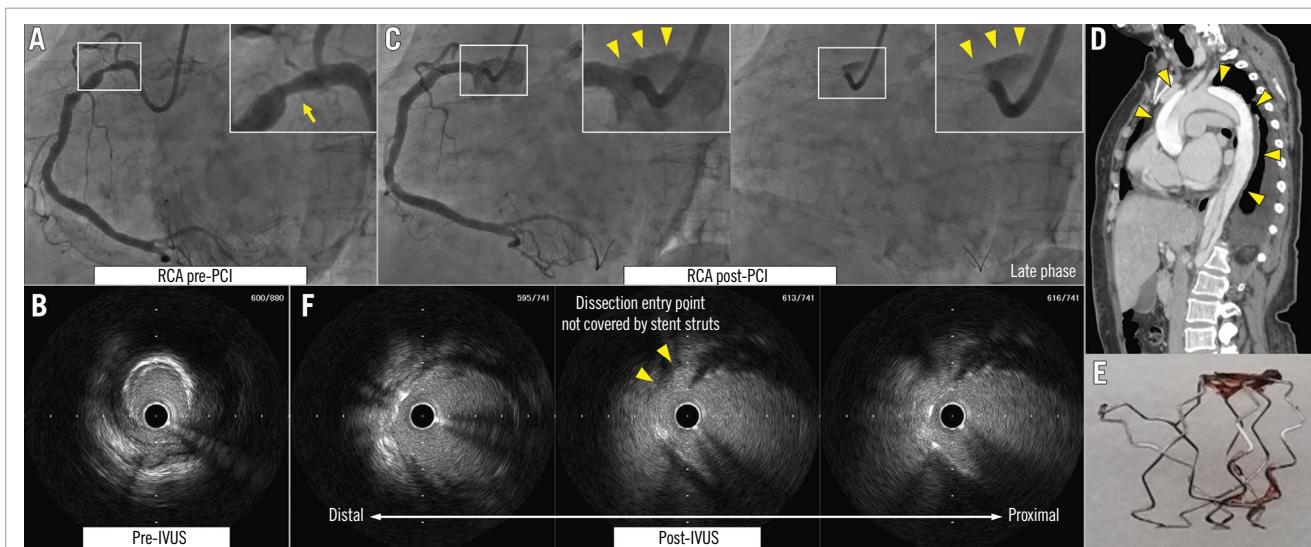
Progression of minor coronary dissection after PCI. A, B) Coronary angiography and IVUS pre-PCI showing eccentric calcified plaques at the stenotic site of the proximal RCA (yellow arrow). C) Coronary angiography post-PCI showing aortocoronary dissection extending from the proximal RCA to the right sinus of Valsalva (yellow arrowheads). D) CT showing Stanford type A aortic dissection (yellow arrowheads). E) Fractured stent from the proximal RCA. F) IVUS post-PCI showing the dissection entry point which was not covered by stent struts (yellow arrowheads). CT: computed tomography; IVUS: intravascular ultrasound; PCI: percutaneous coronary intervention; RCA: right coronary artery
